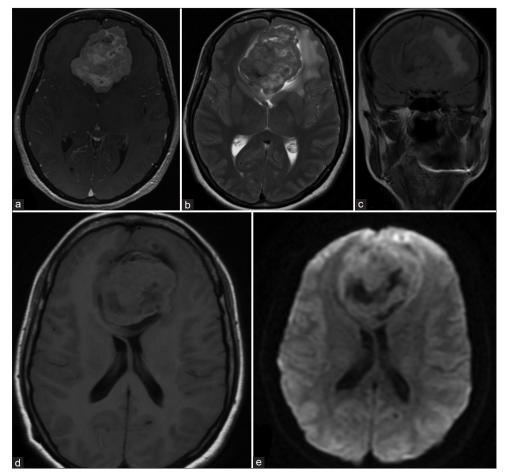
Appearance of the lesion on (a) Axial three-dimensional fast spoiled gradient-echo sequence with contrast matter; (b) Axial T2 PROPELLER sequence; (c) Coronal T2 FLAIR PROPELLER sequence; (d) Axial T1 FLAIR sequence; (e) Axial diffusion-weighted imaging sequence with apparent diffusion coefficient map. FLAIR: Fluid-attenuated inversion recovery.
